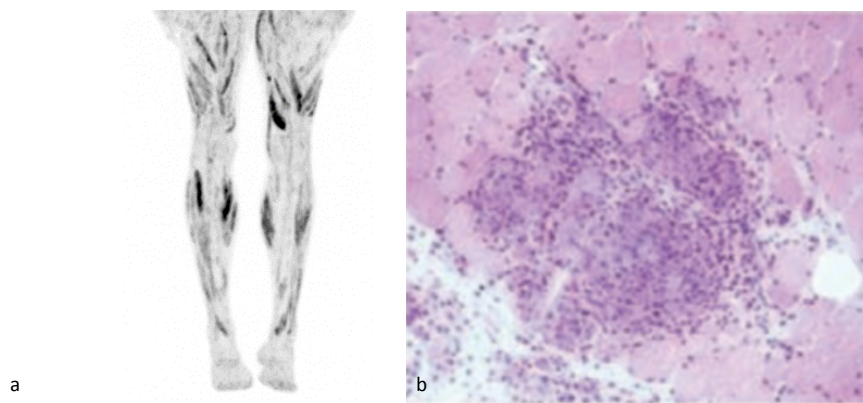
a. Fluorine-18 fluorodeoxyglucose position emission tomography (18F-FDG PET) metabolic activity in the muscles of the lower limbs of a patient with sarcoidosis. b. Biopsy from the left quadriceps muscle of the patient with sarcoidosis showing noncaseating granuloma (with courtesy of Dr. Ruth Keijsers).
